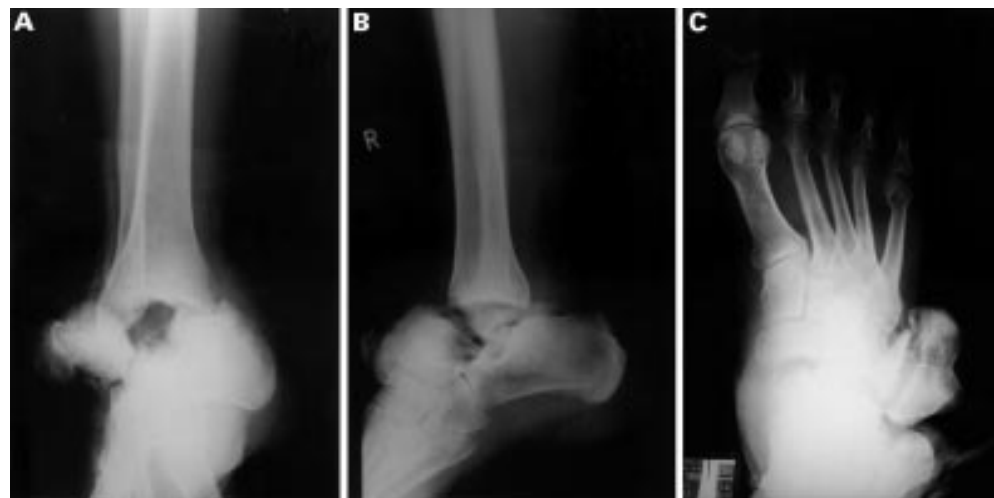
(A)-(C) Anteroposterior and lateral radiographs of the ankle and the foot on admission, demonstrating complete lateral dislocation of the talus and an associated fracture of the fifth metatarsal head.
